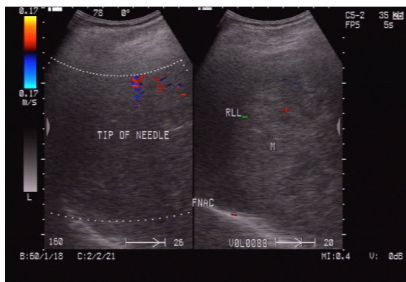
Ultrasound showing FNAC of hyperechoic SOL with irregular margins in right lobe of liver.
